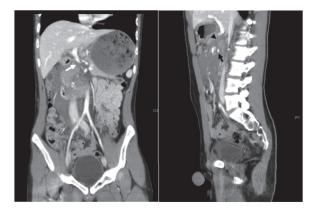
Abdominal computed tomography (CT) with contrast, sagittal and coronal view. (A) Coronal view, hemoperitoneum, interruption of portal vein (PV) with luminal narrowing (white arrow), and pancreatic injury. (B) Sagittal view, PV was encased by hematoma (black arrow head), and contrast medium extravasation (black arrow).
